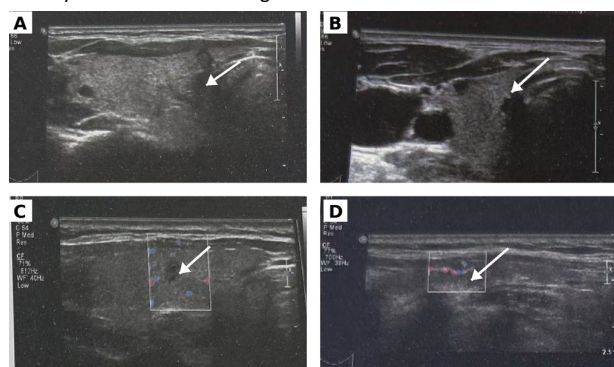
Representative anonymized thyroid ultrasound images. Arrows indicate representative regions of interest or abnormal thyroid lesions. A: heterogeneous thyroid echogenicity; B: thyroid nodule; C: color Doppler ultrasound image of a nodular lesion; D: nodular lesion with visible blood-flow signal. Please replace these panels with original anonymized images from the 2017 dataset if available.
